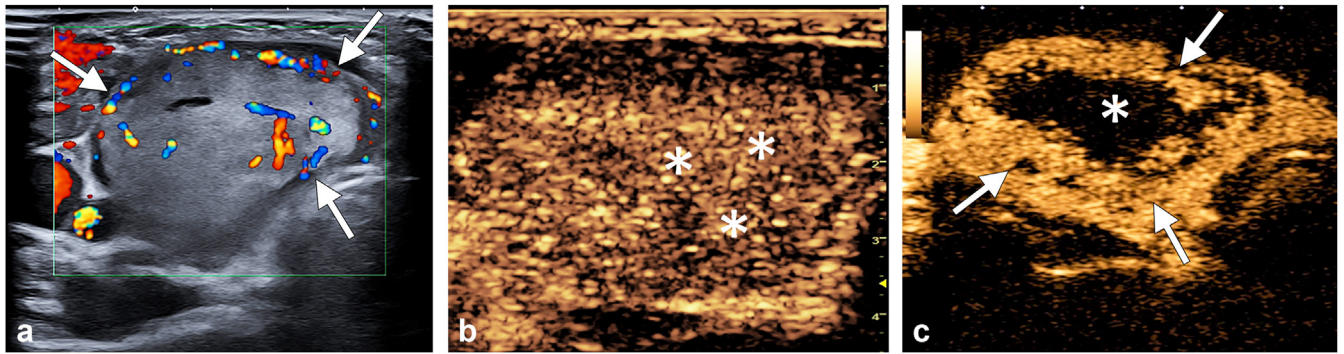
(a) Color Doppler showed main peripheral vascularization (arrows). (b) Contrast-enhanced ultrasound before cryoablation showed homogeneous centripetal enhancement (asterisks). (c) Contrast-enhanced ultrasound 1 week after cryoablation showed homogeneous peripheral enhancement (arrows) and no enhancement in the treated areas (asterisk).
